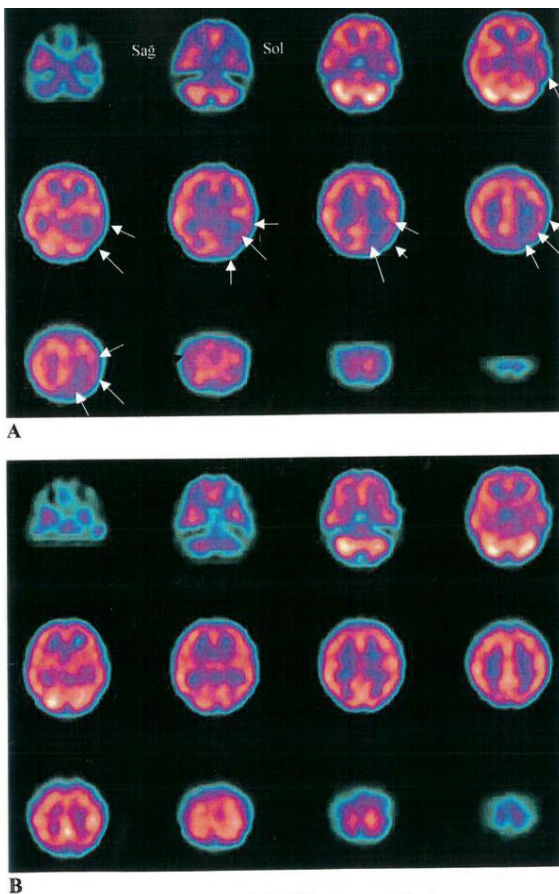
(A,B). In Patient 3, hypoperfusion was observed in left parietal, temporal and occipital areas during ictal stage (A) with axial section by Tc-99m HMPAO SPECT. During interictal stage (B), brain perfusion was normal
